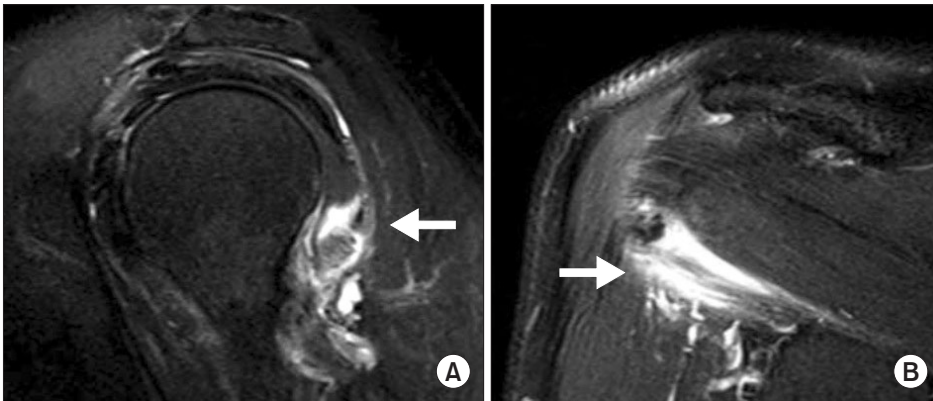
Preoperative magnetic resonance imaging showing a teres minor tear at its musculotendinous junction (arrows). (A) Sagittal view. (B) Oblique coronal view.
